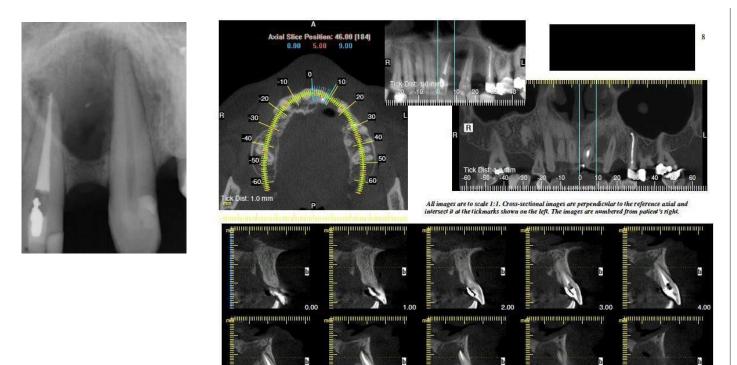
Follow up (A) Periapical radiograph and (B) CT scan of maxillary teeth showing signs of bone healing and reduction in the size of periapical radiolucency.
